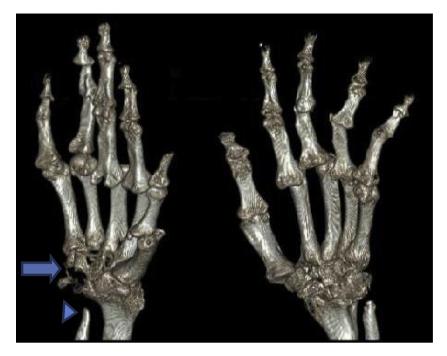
Three dimension computed tomography (3DCT) (posteroanterior view) hand and wrist of a 60 year old rheumatoid arthritis patient with 15 years disease duration. Arrow shows erosion of the carpal bones (scored 4) with amalgamation of the carpal bones. Arrow head shows erosion of the ulna (scored 7).
